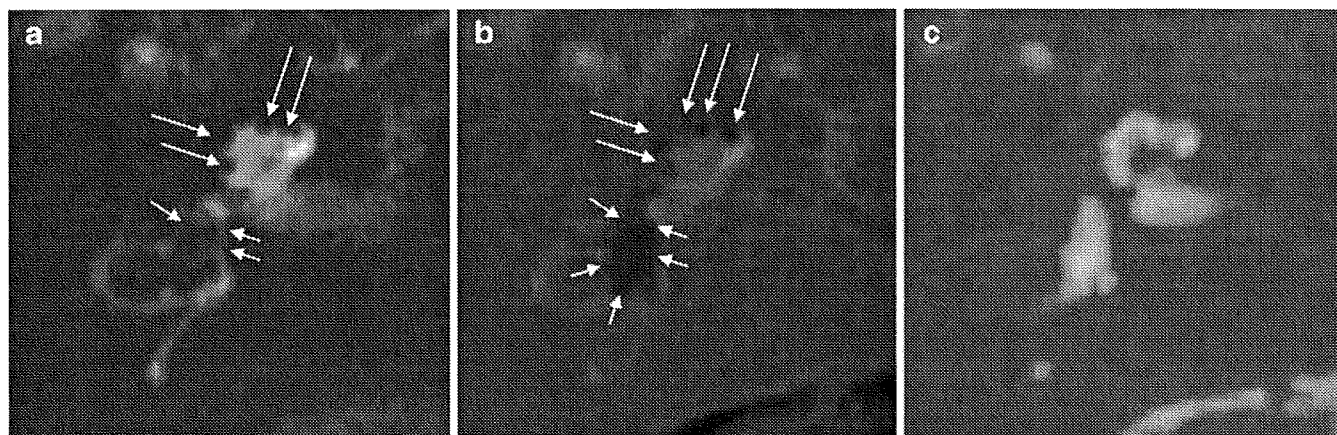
A 42-year-old man with Meniere's disease. All images were obtained 24 h after the intratympanic injection of Gd-DTPA. (a) 3D-FLAIR (9,000/134/2,500) shows severely enlarged endolymphatic space in the cochlea (arrows) and in the vestibule (short arrows). The boundary between endolymphatic space and surrounding bone is unclear. (b) A 3D-real IR sequence (9,000/134/1,700) visualizes
